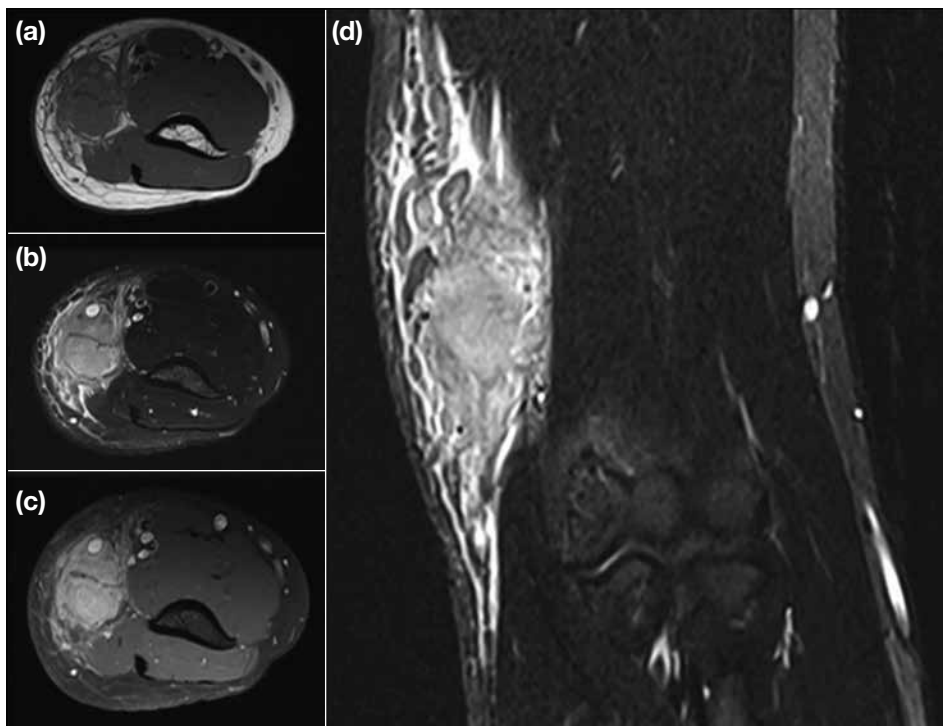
Magnetic resonance imaging of left elbow in case 2. (a) Ill-defined subcutaneous mass with intermediate signal on T1-weighted axial image, (b) hyperintense signal on T2-weighted axial image with encasement of basilic vein, (c) mild homogeneous enhancement on T1-weighted fat suppressed image with contrast, and (d) medial epitrochlear location with extensive surrounding subcutaneous fat strandings and oedema on coronal T2-weighted short tau inversion recovery image.
